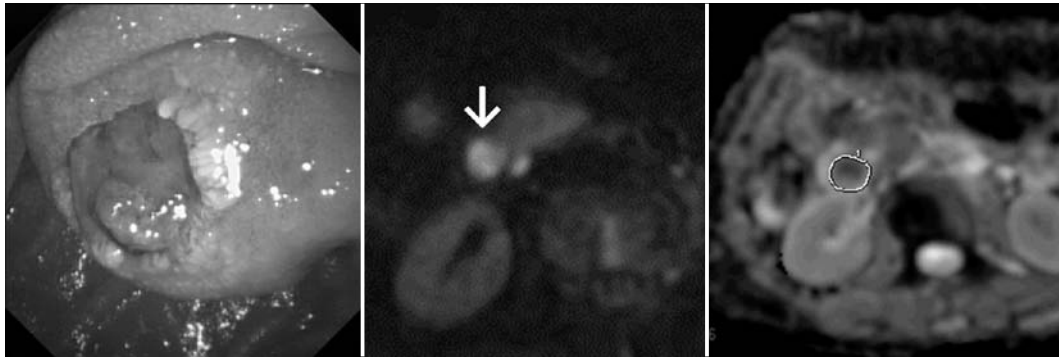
Endoscopy and diffusion-weighted magnetic resonance imaging of Case 6 (adenocarcinoma). The endoscopy showed an obviously elevated lesion with an erosive depression in the ampulla of Vater (left). Diffusion-weighted magnetic resonance imaging revealed that the tumor, which was markedly hyperintense relative to the adjacent duodenal wall (white arrow), was easily identified (center). The apparent diffusion coefficient (ADC) value was calculated by manually placing a region of interest (ROI) over the ampullary lesion. The ROI was drawn by freehand along the outline of the lesion identified in the DWI images used for qualitative analysis and was set as large as possible (right).
